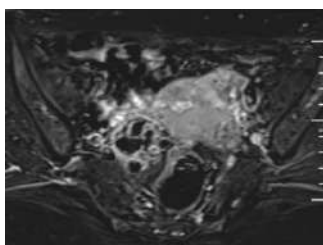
MRI showing endometriotic cysts and nodule over & Infiltrating rectum.png
